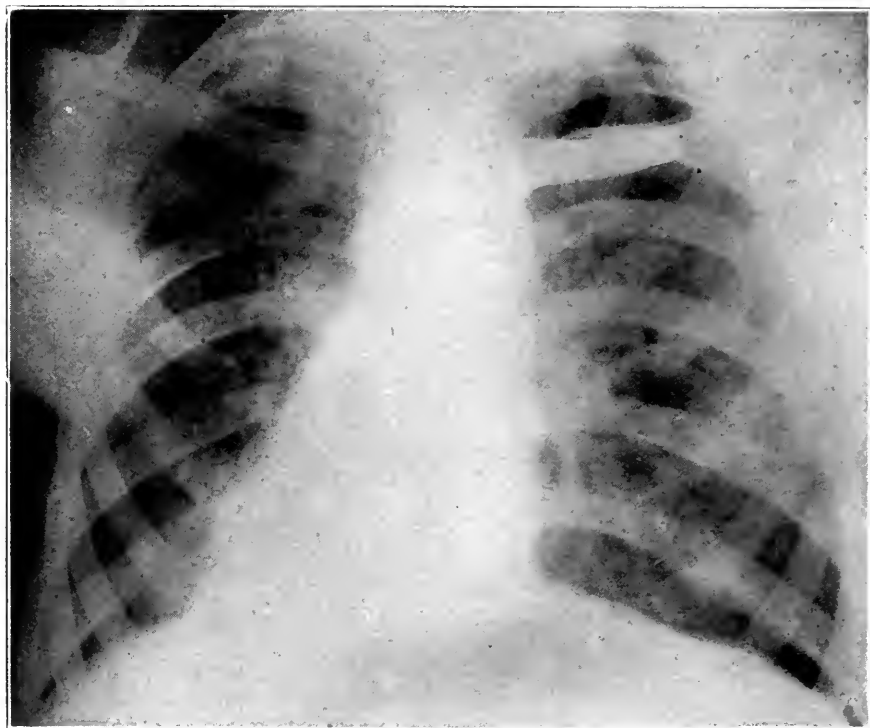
Case 828. Roentgenogram of the lungs in an advanced case, showing a large, very typical cavity in the left apex with smaller multiple cavities in the right apex.
